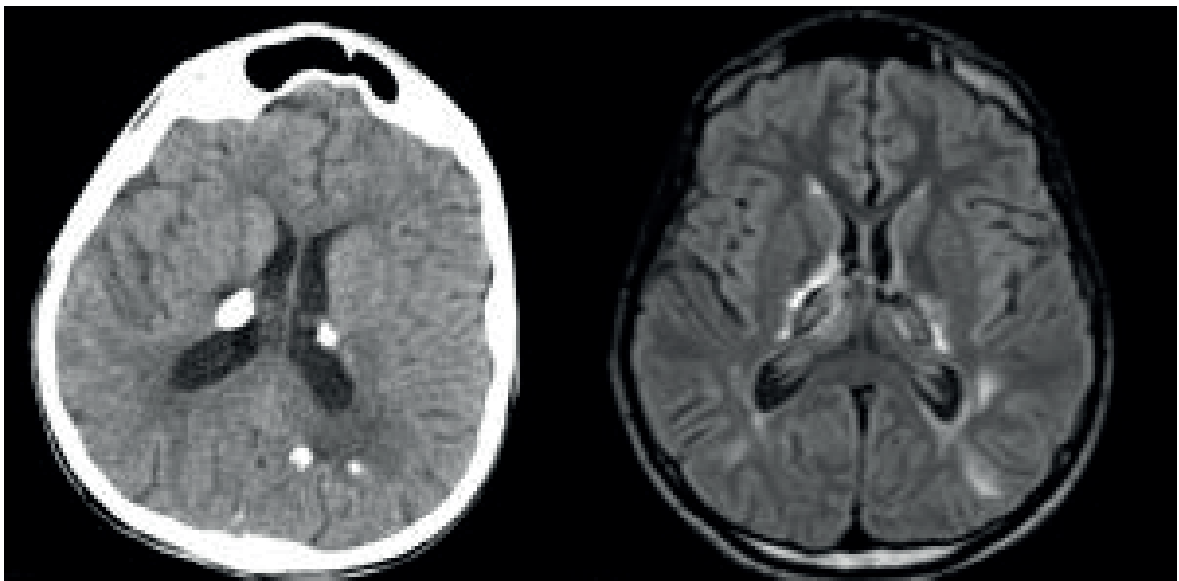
Cranial computerized tomography scan showing variable and asymmetrically distributed calcifications (Left); Magnetic resonance imaging showed ischemia, gliotic regions and calcifications in FLAIR series (Right).
